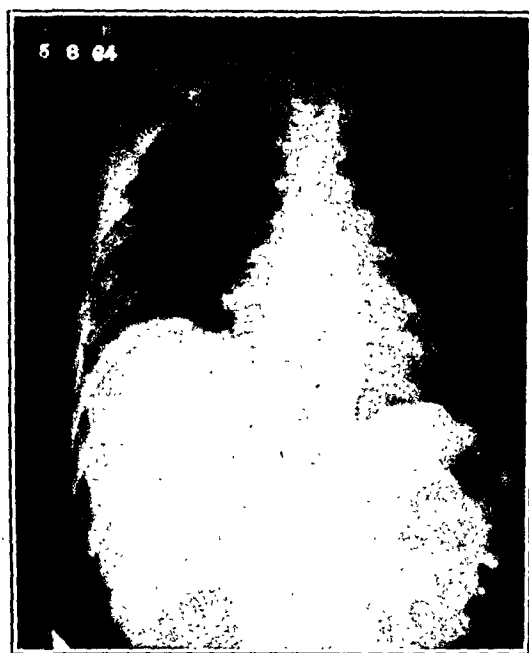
Roentgenogram taken on May 1, 1934. Fig. 4.—Roentgenogram taken on May 4, 1934.
